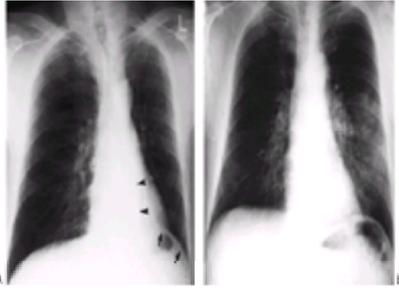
A: Classic radiographic findings of left lower lobe collapse. These include volume loss (demonstrated by a shift of the mediastinum, heart, and trachea to the left), a triangular opacity in a retrocardiac location (*black arrowheads*), and silhouetting of the medial portions of the left hemidiaphragm. Only the lateral portion of the hemidiaphragm (*black arrows*) is delineated. B: In a radiograph obtained after chest physical therapy, the left lower lobe collapse has resolved. The shift of the mediastinum and the triangular retrocardiac opacity are no longer present. The left hemidiaphragm is identified medially.
